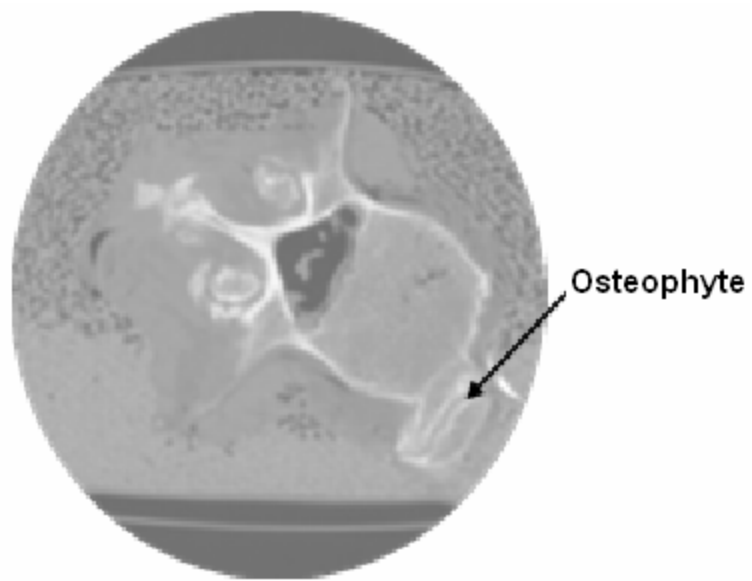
CT image showing an osteophyte that developed off of a vertebral body
